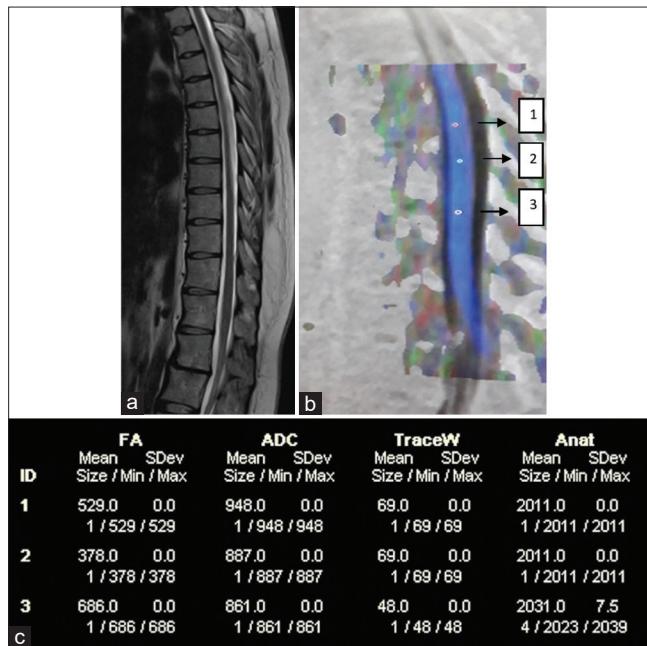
(a) Magnetic resonance imaging T2-weighted sagittal image in a healthy control showing normal spinal cord. (b) Diffusion tensor imaging image showing placement of three regions of interest. (c) Chart showing normal fractional anisotropy and apparent diffusion coefficient values at the three regions of interest
